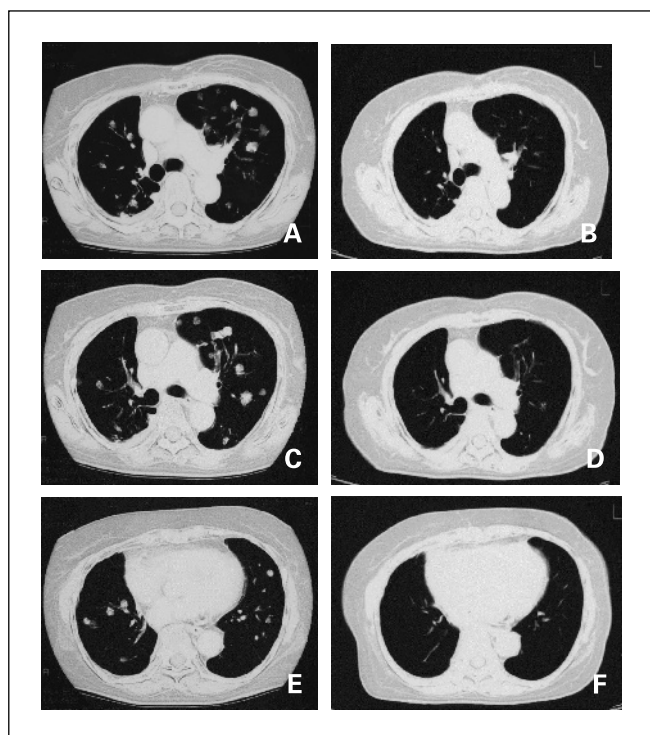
Example of response to gefitinib in a representative patient with recurring NSCLC after three lines of chemotherapy. Computed tomography slices before gefitinib treatment (A, C, and E) and after 8 weeks of gefitinib treatment (B, D, and F).
